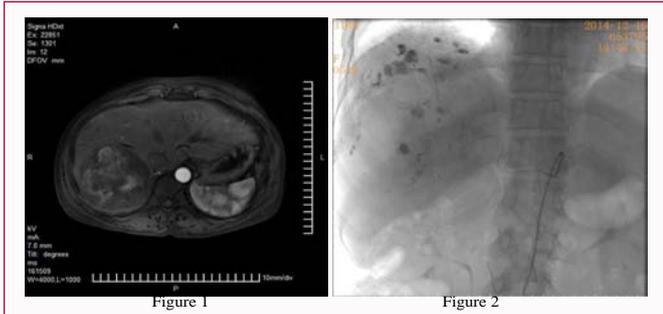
The enhanced MRI picture when patient came to our hospital for the first time on December 11, 2014, which showed space occupying lesion in the right lobe of liver (9.86 cm × 9.29 cm), with intrahepatic metastasis. And we performed transcatheter hepatic arterial chemoembolization (Figure 2).
